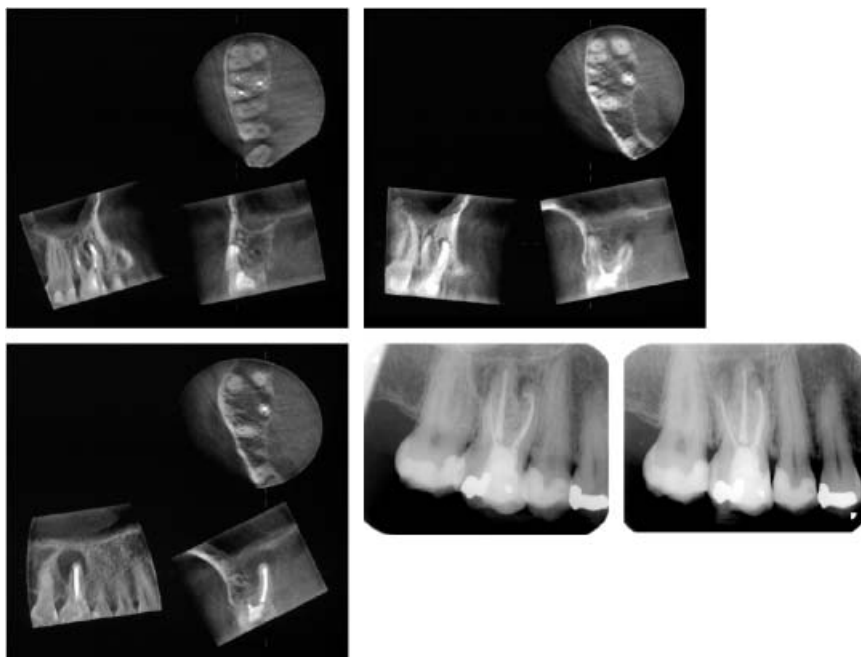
Compared with periapical radiographs, limited cone beam computed radiography displays the roots and their closest surroundings without overlying structures and without distortions. Measurements can be accurately made.
